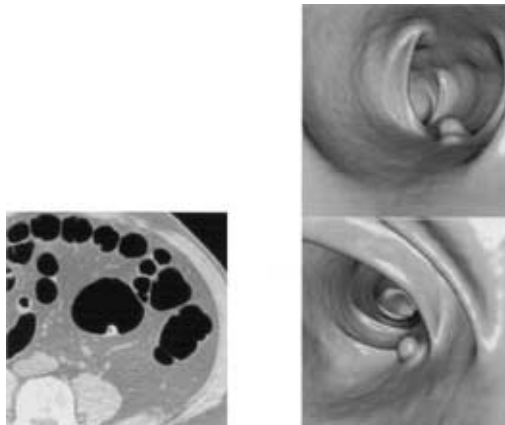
Axial CT image (0.75mm slice) showing a polyp in the descending colon and the virtual colonoscopy images looking at the same lesion from both directions. Images courtesy of Siemens UK.
